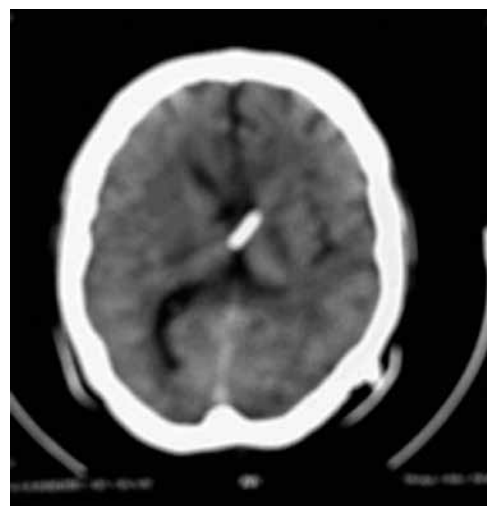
Control head CT without contrast after ventriculoperitoneal shunt.
